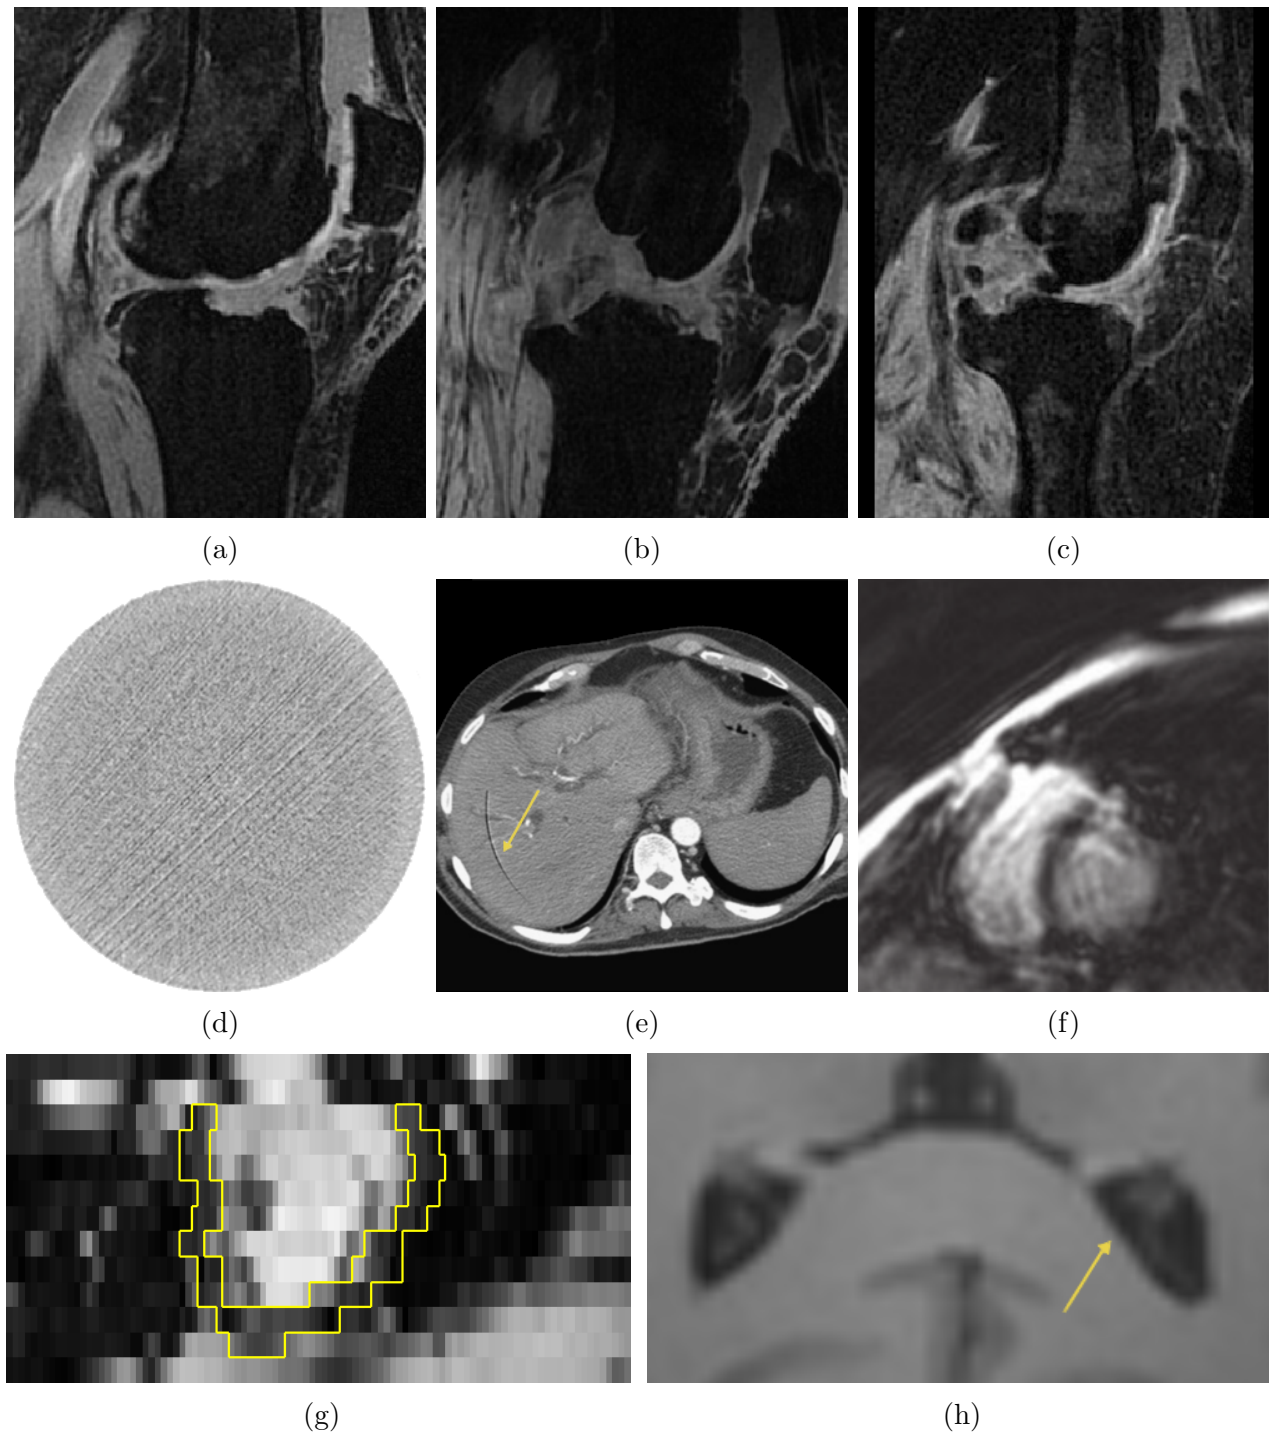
Examples of some of the artifacts and potential challenges. In (a), (b) and (c), tissue inhomogeneities can be seen, in addition to different levels of noise, different intensities for similar tissues and overlapping intensities between different tissues. (d) shows a streaks and (e) shows rings in CT images. Motion artifacts produce ghosting and blurring of the image in (f) and can also cause discontinuities between slices as seen in (g). Partial volume effects can lead to blurry boundaries such as in (h).
